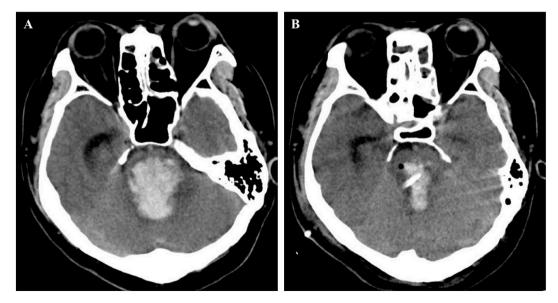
Preoperative and postoperative CT images of patients with PPH. Preoperative head CT images (A). postoperative head CT images (B).
